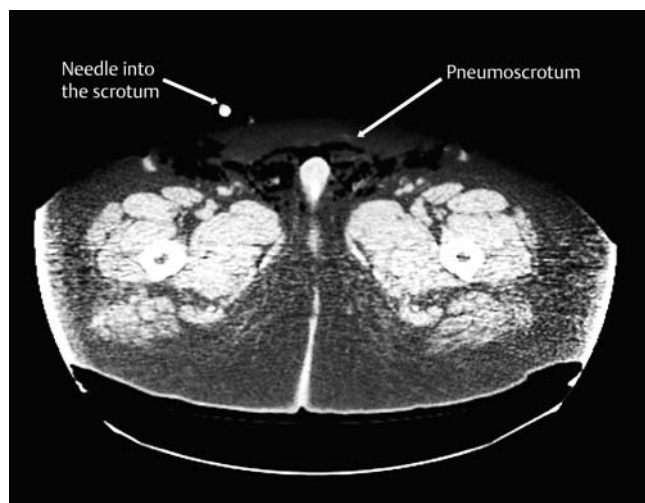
Abdominal computed tomography imaging of scrotal emphysema (pneumoscrotum).
